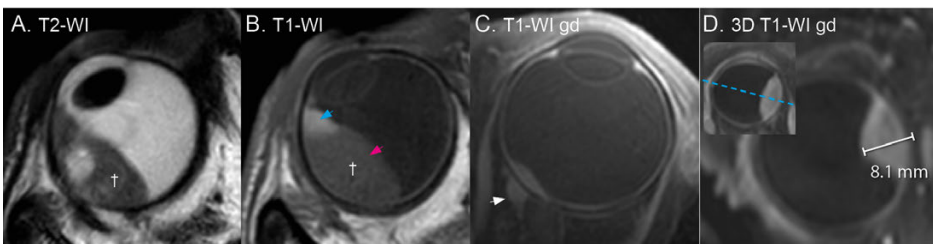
(A,B) patient with necrosis (A) in a bipartite uveal melanoma (cross). The amelanotic part (B), pink arrow) is isointense, while the melanotic part (B), blue arrow) is hyperintense compared to the choroid on T1. (C) Extraocular extension (white arrow) is best visualised on the contrast-enhanced T1-weighted scan with fat suppression. (D) A volumetric scan allows for three-dimensional visualisation of the tumour and surrounding structures and provides the most accurate dimension measurements (line) as the measurement plane (D) can be reconstructed perpendicular to the sclera (dotted line).
